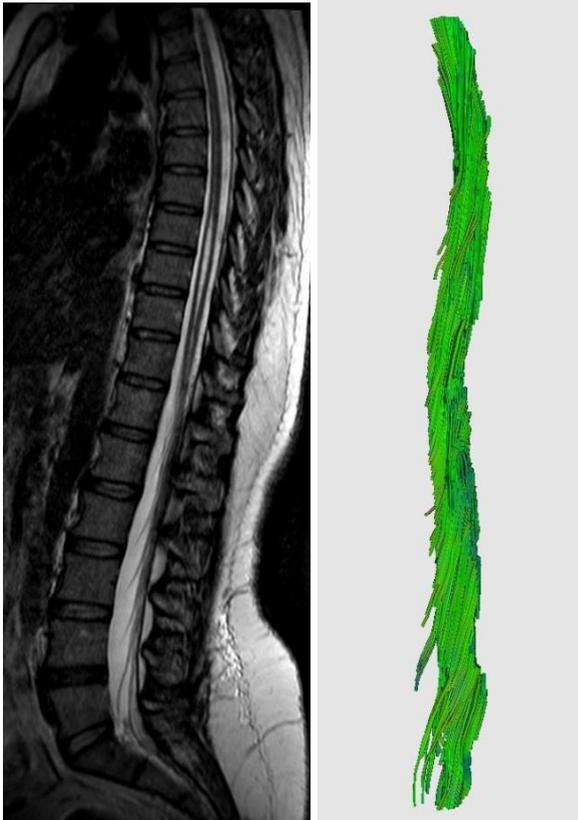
Centromedullary canal, MRI in sagittal T2 sequence and fibre tracking. Anatomical variant to normal (normal tracking).
